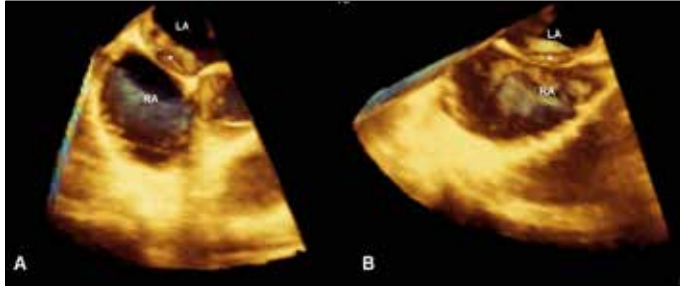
Three-dimensional transesophageal echocardiography view of a double interatrial septum
